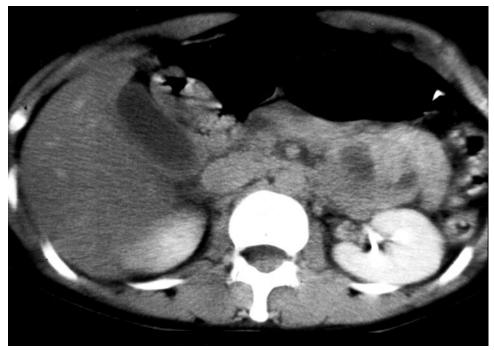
CT scan of the abdomen showing left extraadrenal mass.
